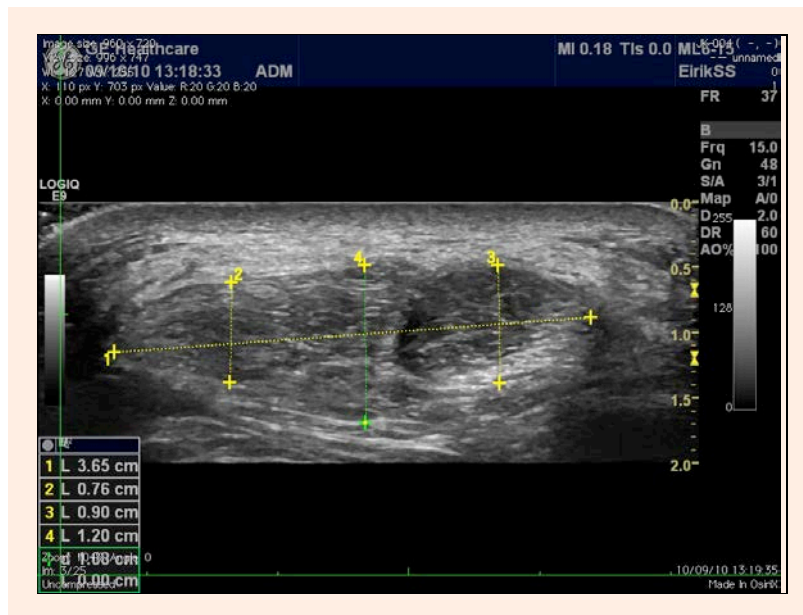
Measurements of width and thickness in the proximal part of patellar tendon, grey-scale ultrasound – transverse scan. (Photo by Salvesen ES).
